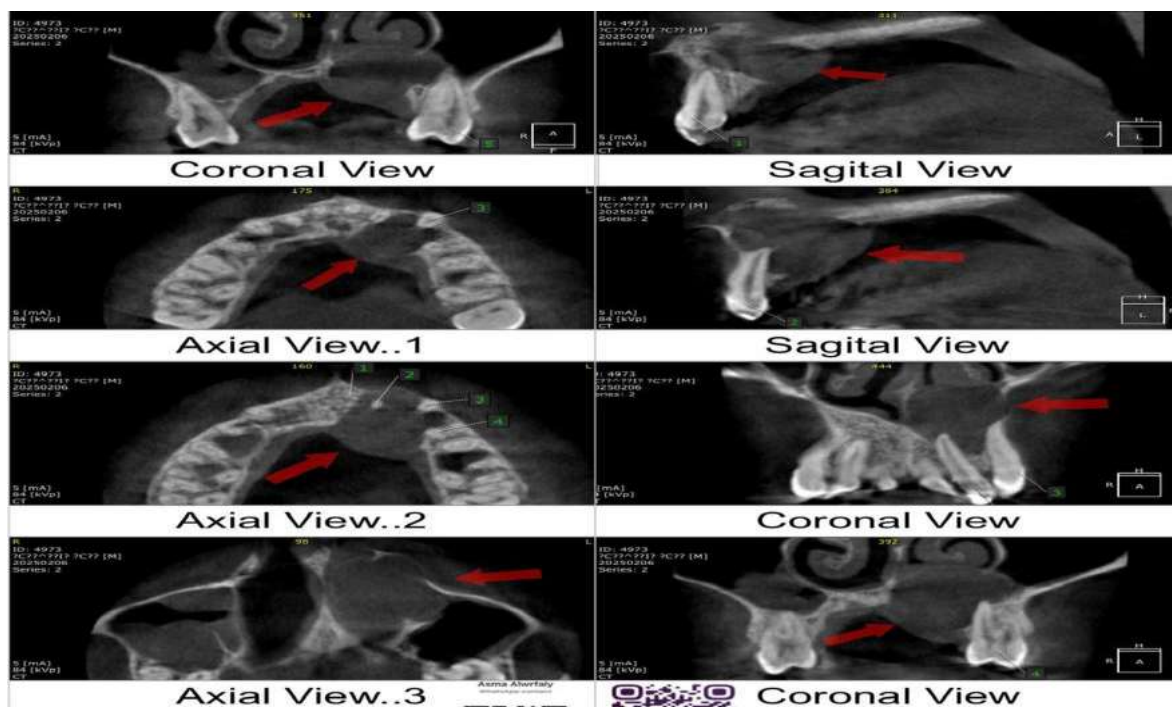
Cone-beam computed tomography (CBCT) images. (A) Axial section, (B) Coronal section, (C) Sagittal section, demonstrating the full extent of the cystic lesion and its relationship with the palatal bone and nasal floor.
